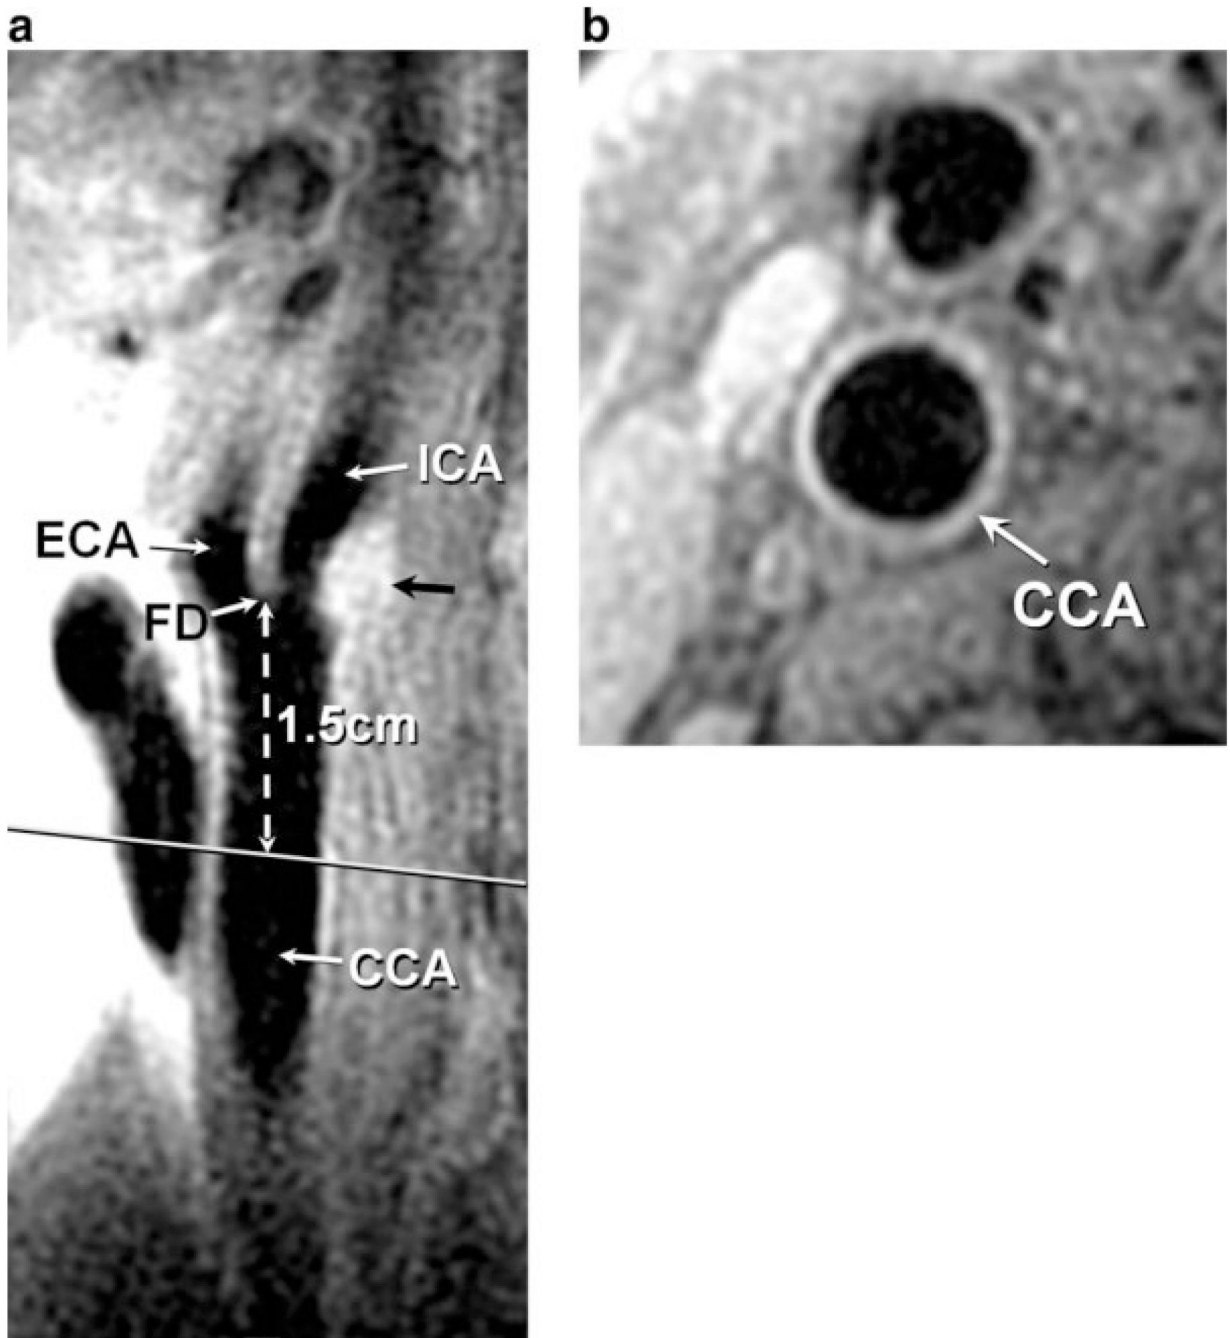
Slice acquisition through the distal right CCA. A long axis BBMRI image through the carotid bifurcation (a) showing the plaque in profile (black arrow) was used to position a T1-weighted BBMRI slice 1.5 cm below the FD (b). This was also done on the left side.
